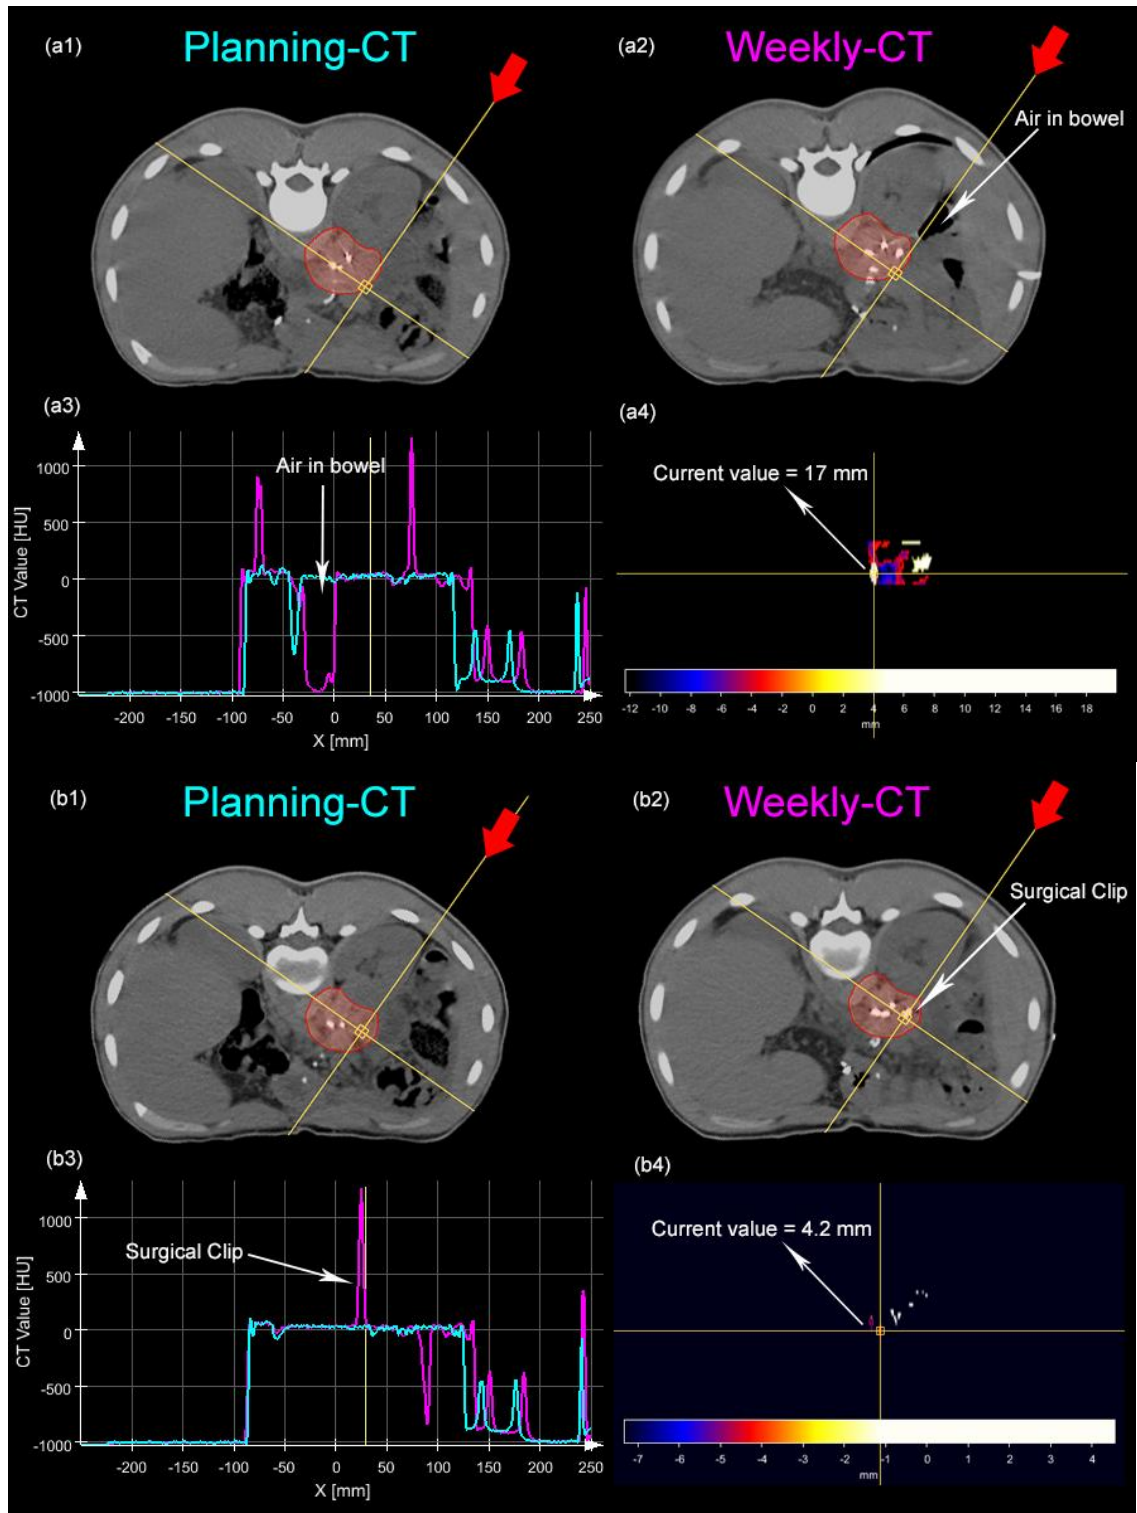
Point analysis for Patient F. (a) For Weekly-CT1, field 2. (b) For weekly-CT3, field 2. The bowel changes effect from planning-CT (a1) and weekly-CT (a2) can be observed in (a3) CT value (HU) and also in (a4) accWEPL difference map. The current value is the accWEPL value for that specific beam indicated by red arrow. The movement of surgical clip in planning-CT (b1) and weekly CT (b2) can be observed and the resulting effect in (b3) CT value (HU) and (b4) accWEPL difference map. Again one can compare the area of the difference map filled with variations, for weekly-CT1 a lot of points with variations but in weekly-CT3 most of the area is black which represents points within ± 3 mm.
